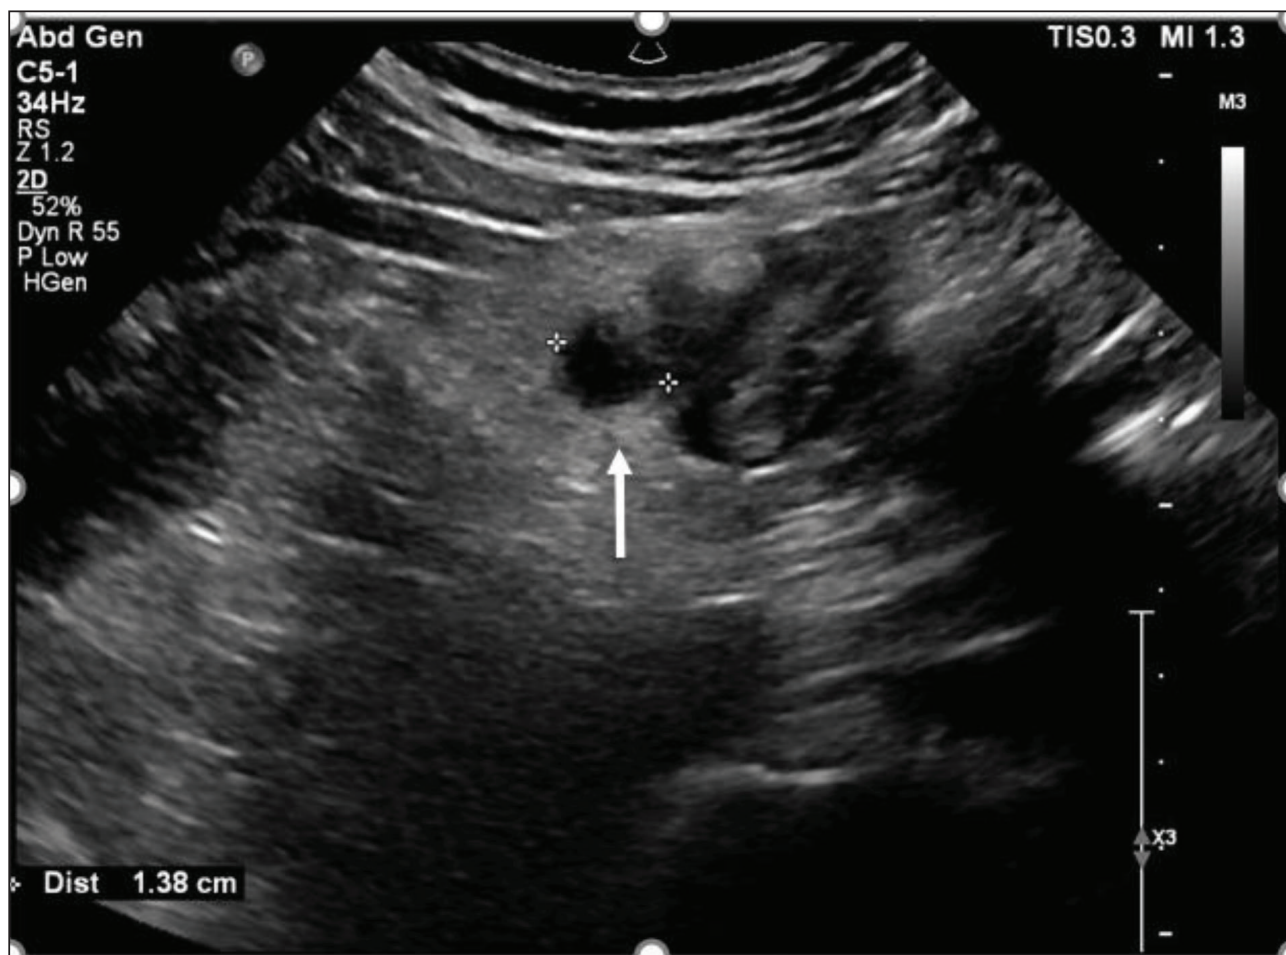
Abdominal ultrasound demonstrating focal thickening of the bowel wall in the right lumbar region measuring up to 10 mm, with surrounding inflammatory fat changes and a diverticular out-pouching (arrow), consistent with localized inflammatory changes.
